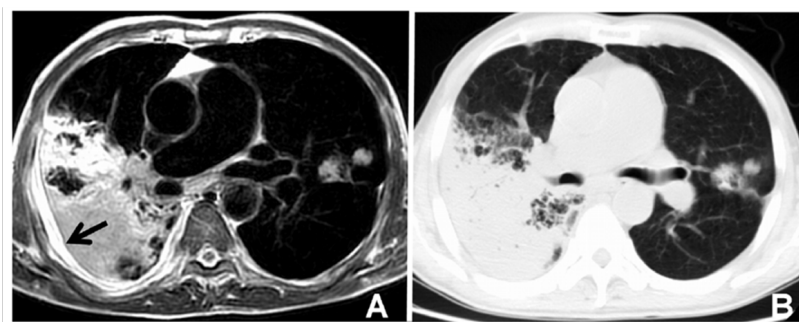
Example of pulmonary tuberculosis on MRI showing heterogeneous texture (A) that appears homogeneous on CT (B). From Zeng J, et al. *Int J Infect Dis* 2019;82:138-146
